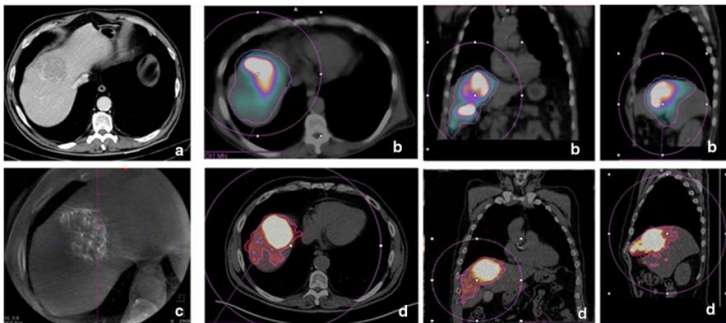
^{99m}Tc -MAA SPECT/CT and CBCT to optimize dosimetric planning for SIRT. (a) Contrast-enhanced computed
